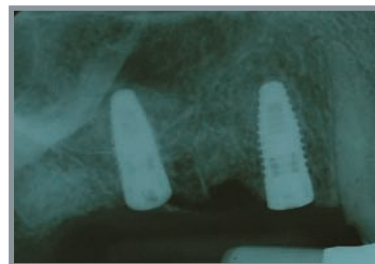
Post-operative Radiograph; Implant placement to first premolar and simultaneous indirect sinus lift with CAS-kit (Hiossen) in first molar position.
